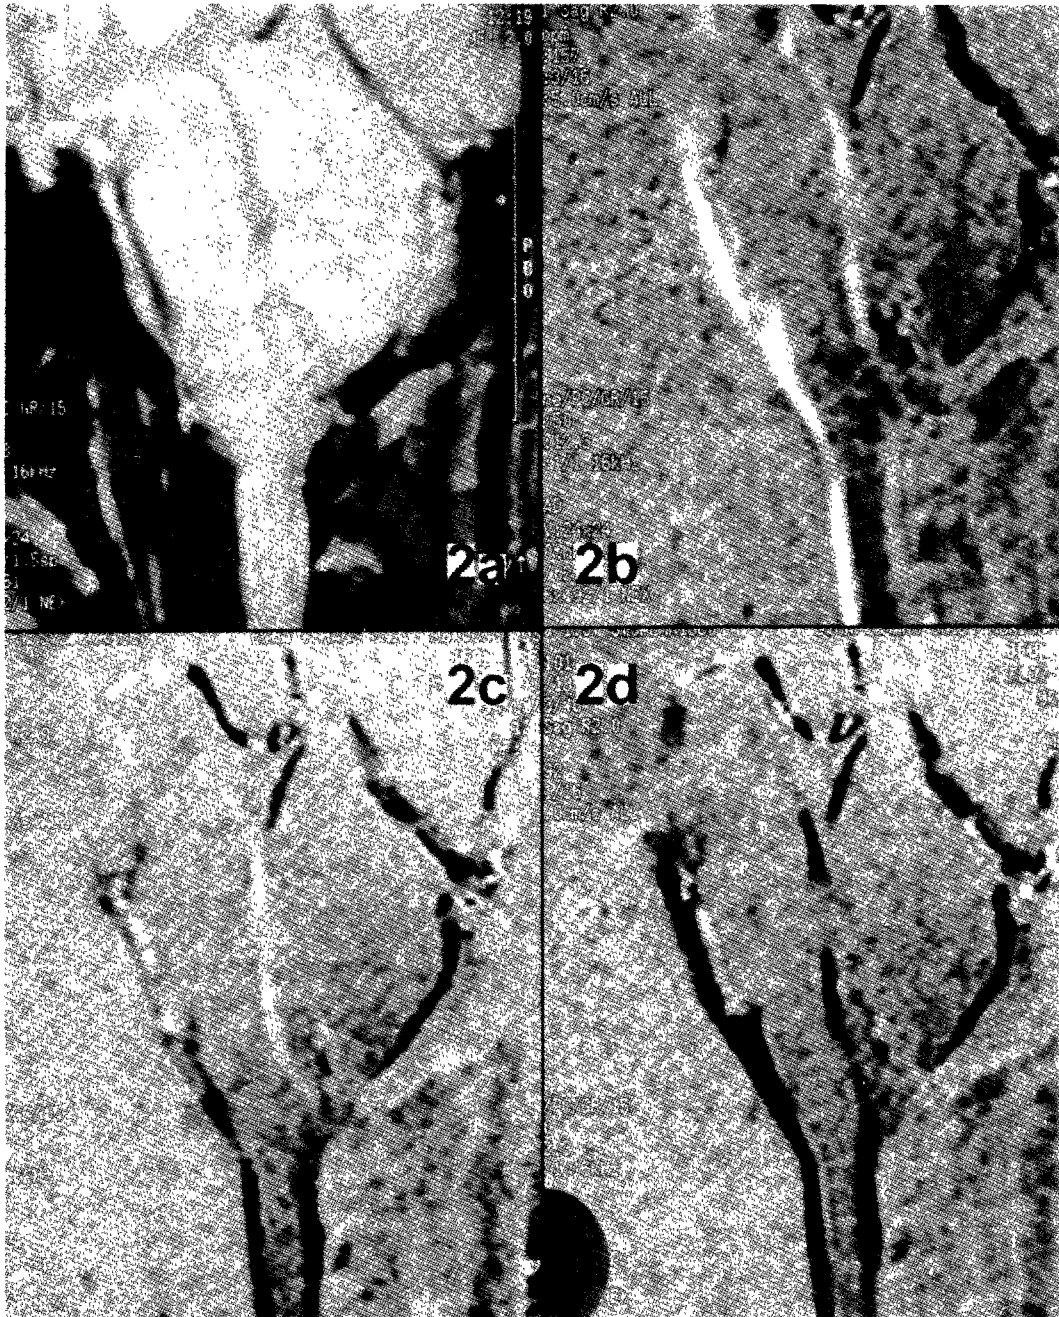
Sagittal plain and velocity-encoded images of aqueductal level in normal person. A sagittal Plain MR image showing the anatomical detail around the aqueduct in 2a. Systolic peak flow(white) is seen in 2b, and diastolic peak flow(black) is seen in 2d. Inversion of systolic to diastolic flow is seen in 2c(Note signal changes starts at the center of aqueduct).
